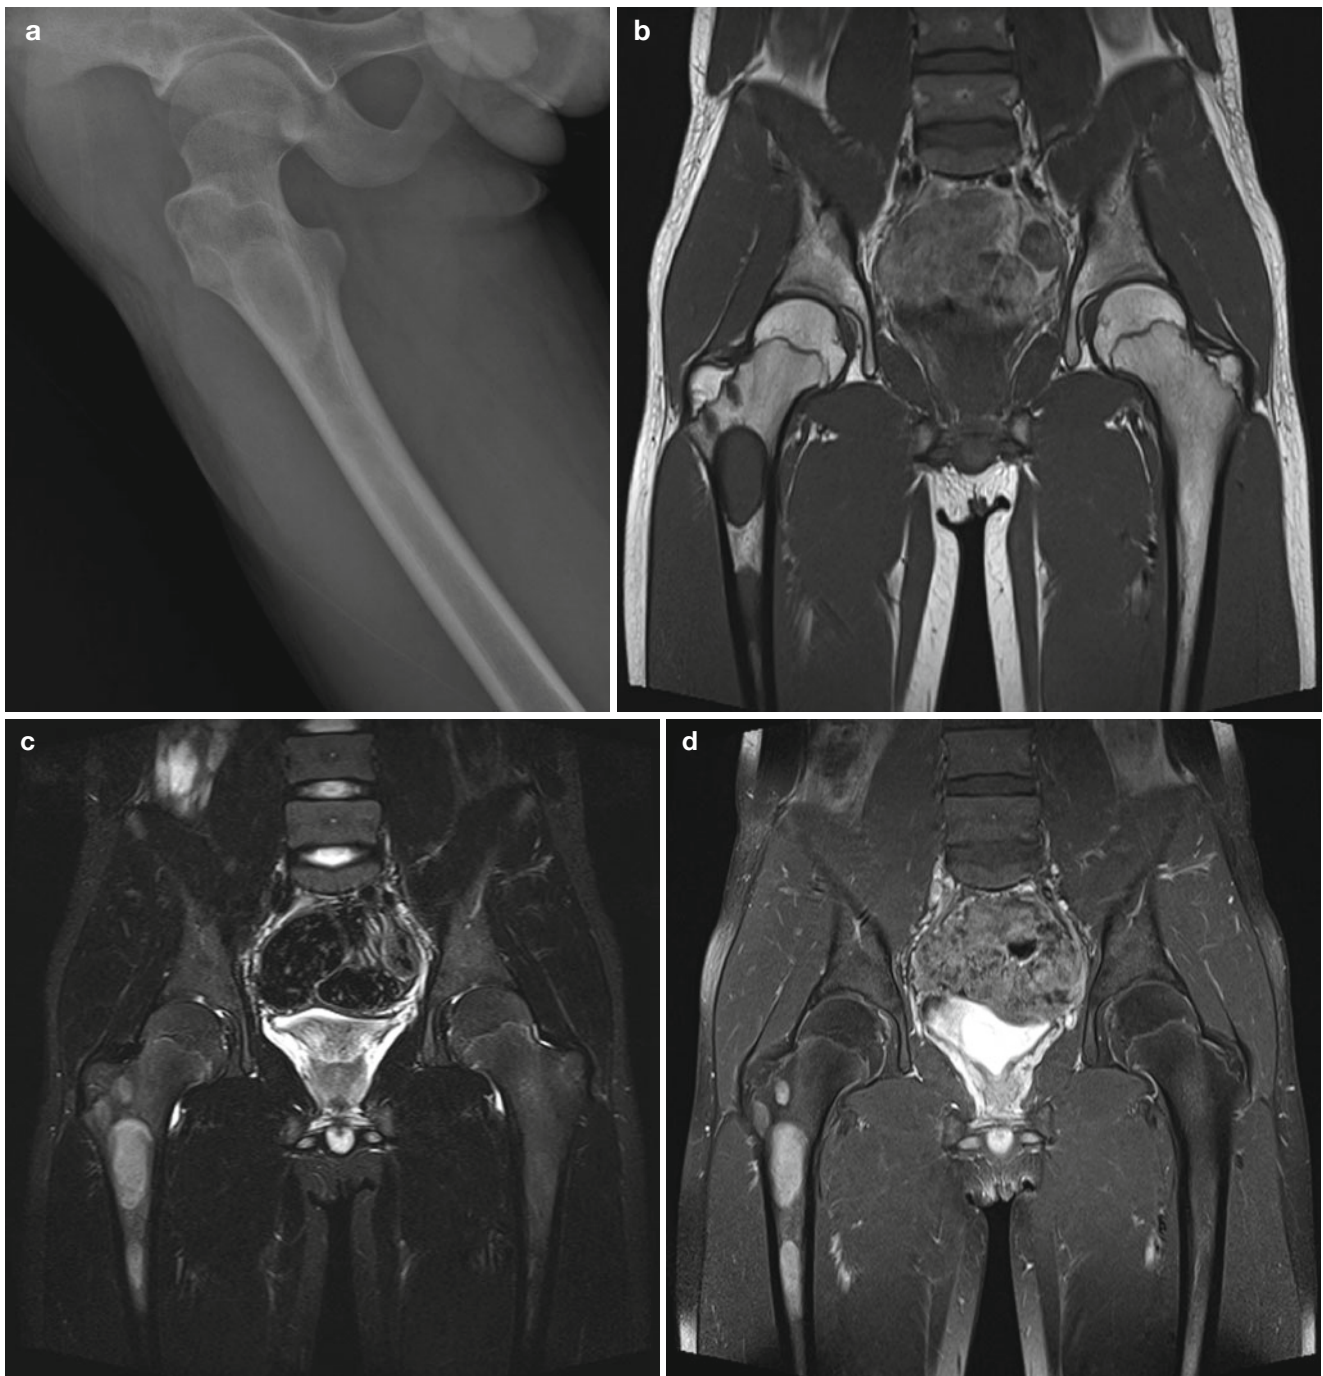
Fibrous dysplasia.* (a) A well-demarcated ovoid bony lesion is noted in the right proximal femur with a ground-glass matrix, highly suggestive of fibrous dysplasia. (b–d) MR T1-weighted image (b) shows sharply margined hypointense lesions (at least four in this
